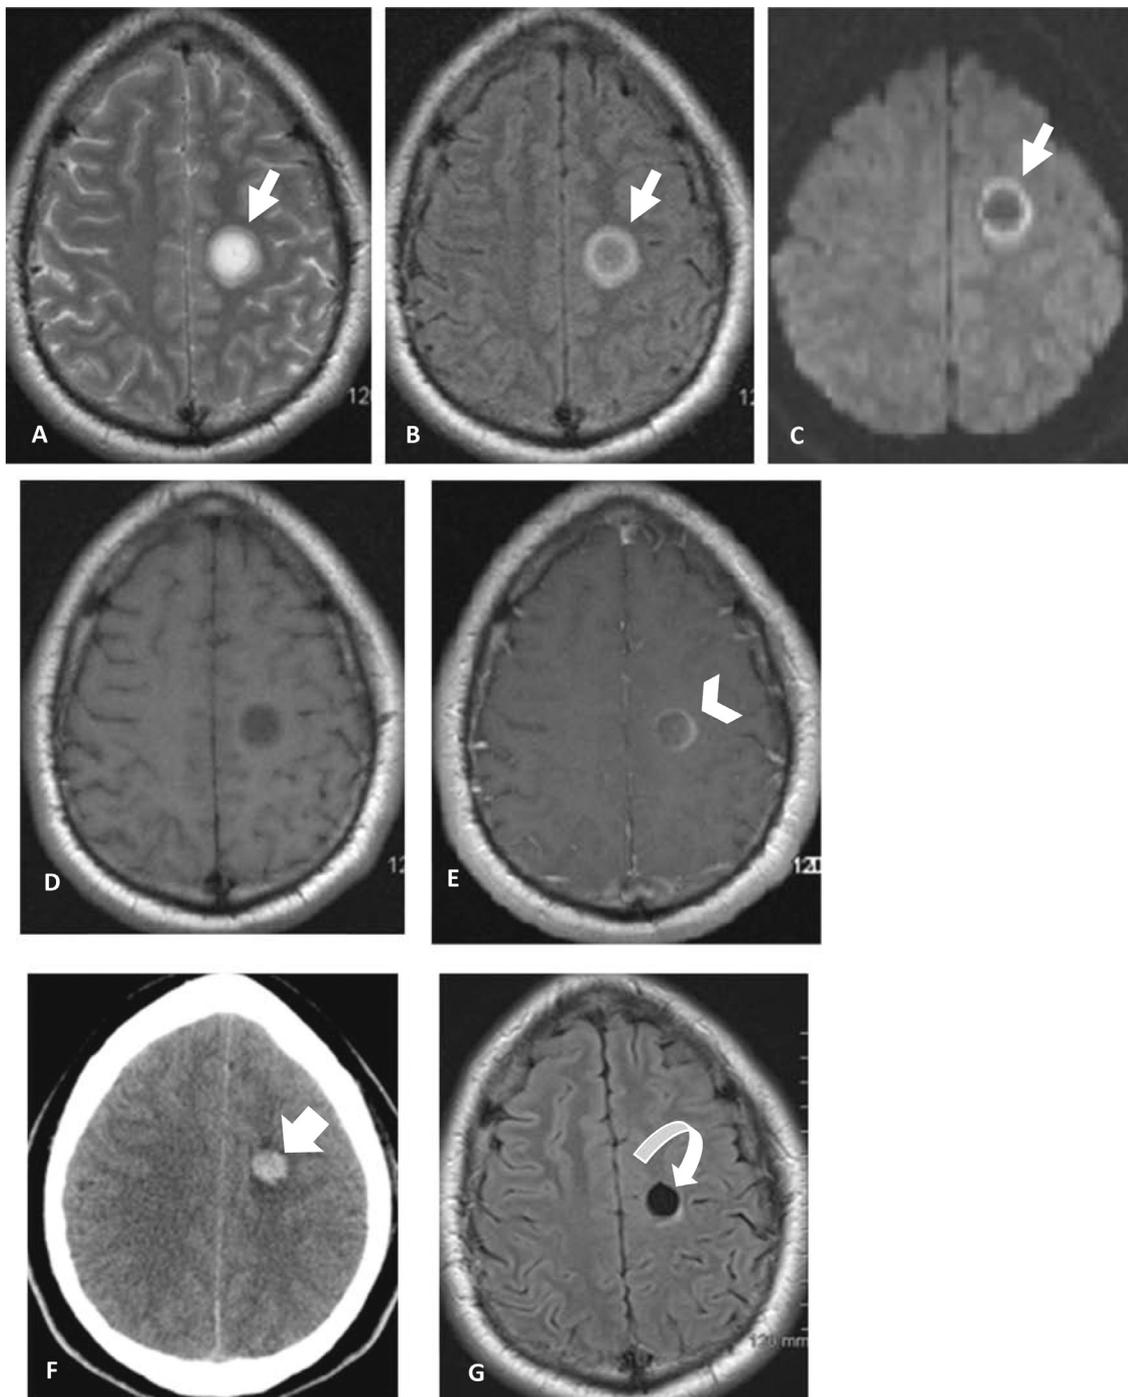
(Case 1): A 36-year-old man presenting with acute right-sided weakness. Axial T2W (A), FLAIR (B), and DWI (C) MRI images showing the typical concentric whorled appearance of Baló's concentric sclerosis in the left frontal white matter or corona radiata (white arrows). Axial precontrast T1W (D) and postcontrast (E) images show concentric layers of enhancement (chevron in E). Axial noncontrast postbiopsy CT image (F) shows hemorrhage into the surgical cavity (thick white arrow). The 4-year follow-up Axial FLAIR MRI image (G) shows the surgical cavity in the left corona radiata (curved white arrow). No new or additional lesions were found. CT, computed tomography.
